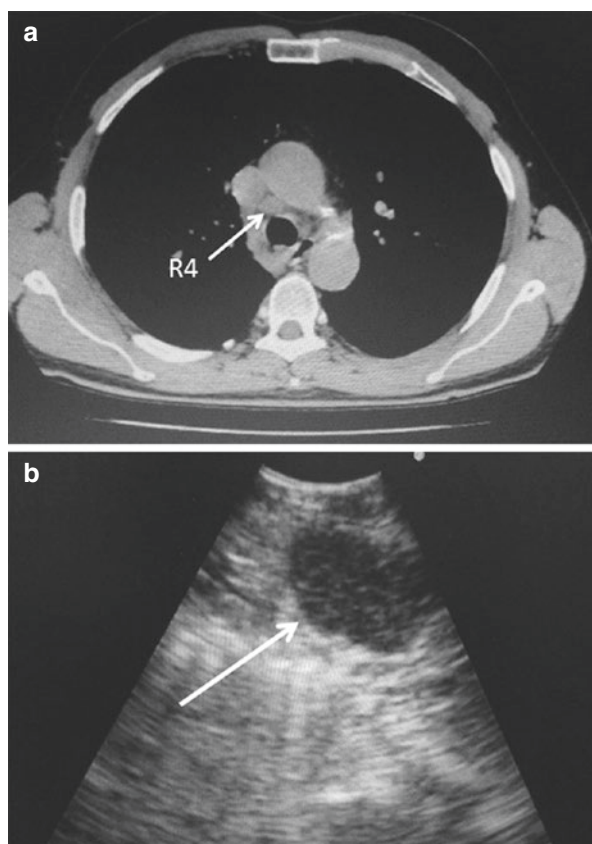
A 47-year-old man with an adenocarcinoma of the right lower lobe presented an enlargement of the paratracheal lymph node (station R4) on computed tomography scan (a). EBUS-TBNA (b) resulted to be positive for metastasis. Photo courtesy of Mario Polverino, MD, and Carlo Santoriello, MD of Pneumology Unit of Scafati Hospital, Scafati, Italy
